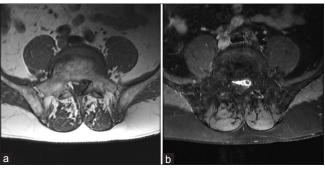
Axial MR images of a cystic lesion on the anterior portion of the spinal chord which demonstrates isolucency on T1-weighted MR images (a) and hyperintensity following gadolinium contrast on T2 weighted image (b)
